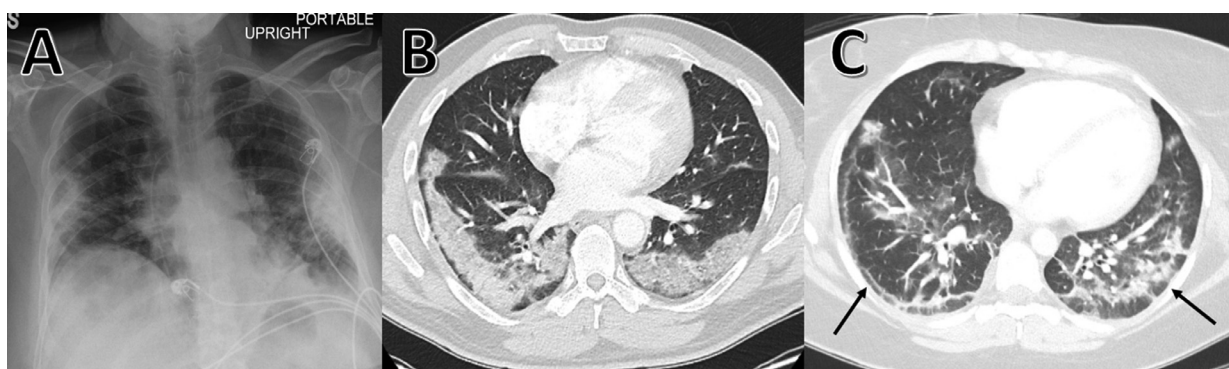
Similarities between the radiological features of organizing pneumonia and COVID-19 pneumonia. (A) Chest radiograph showing bilateral opacities predominantly in the lung peripheries. (B) Chest CT demonstrating bilateral lower lobes consolidation in the subpleural regions. (C) Chest CT revealing bilateral, peripheral, ill-defined patchy GGOs and consolidations in a peribulbar pattern. Reverse-halo signs (black arrow) are seen peripherally.
